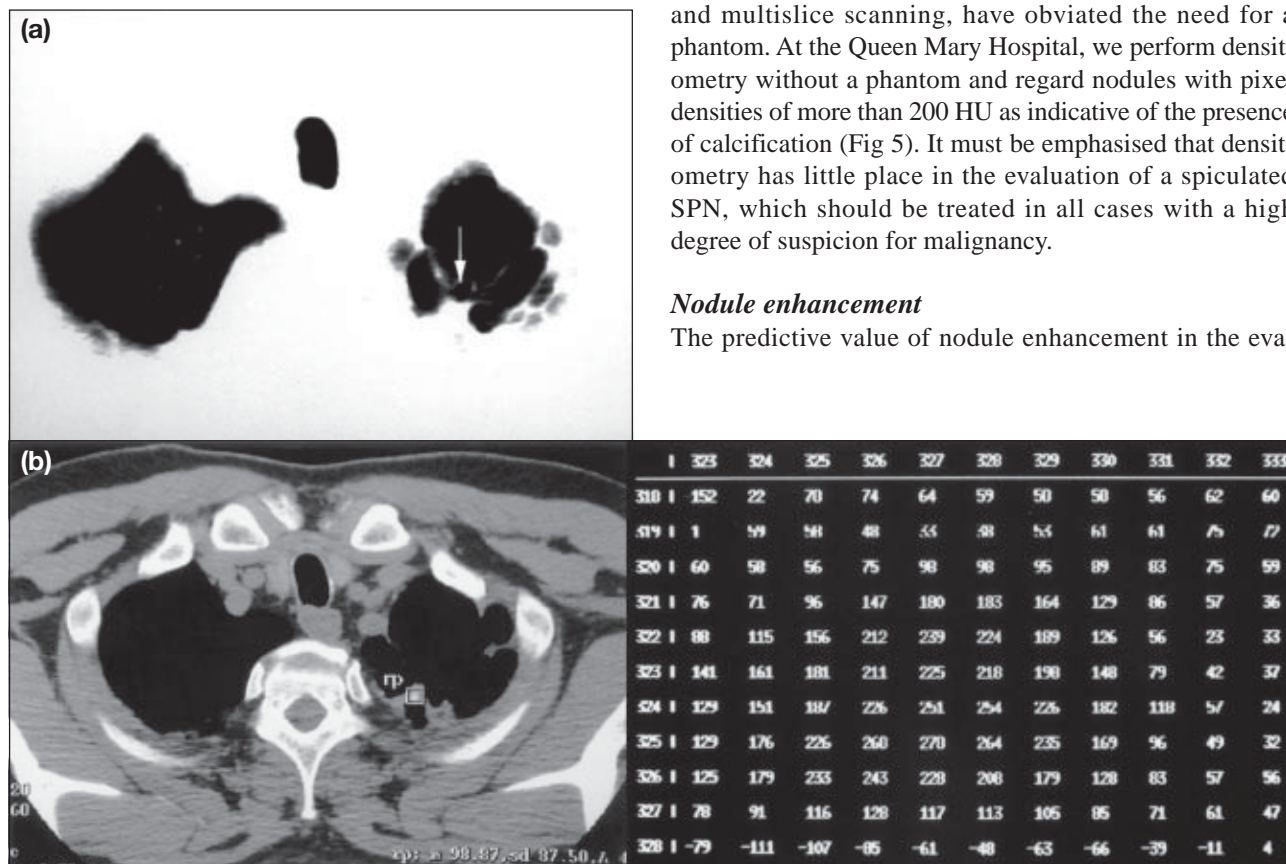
Low-dose computed tomograms of the thorax
